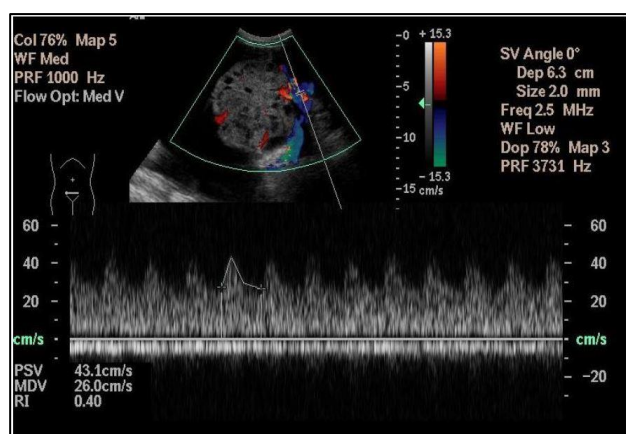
Doppler evaluation revealing evidence of low resistance blood flow (R.I-0.4) within solid portion of adnexal mass.
